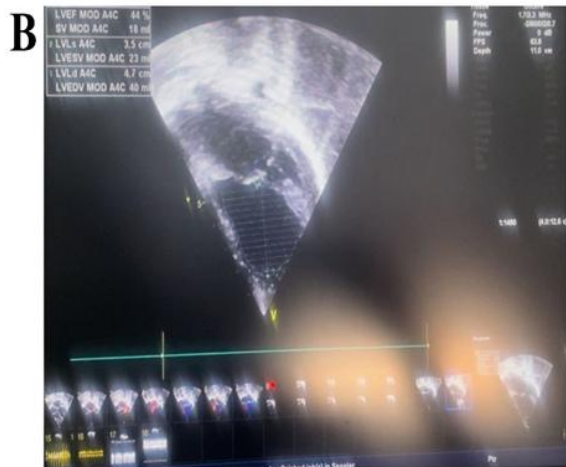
Echocardiographic assessment performed using the GE Vivid 9 system. (A) Evaluation of diastolic dysfunction using 2D echocardiography with mitral valve E/A ratio analysis. (B) Systolic function assessment demonstrated a marked reduction in left ventricular ejection fraction using Simpson's biplane method in 2D echocardiography and M-mode ejection fraction.
